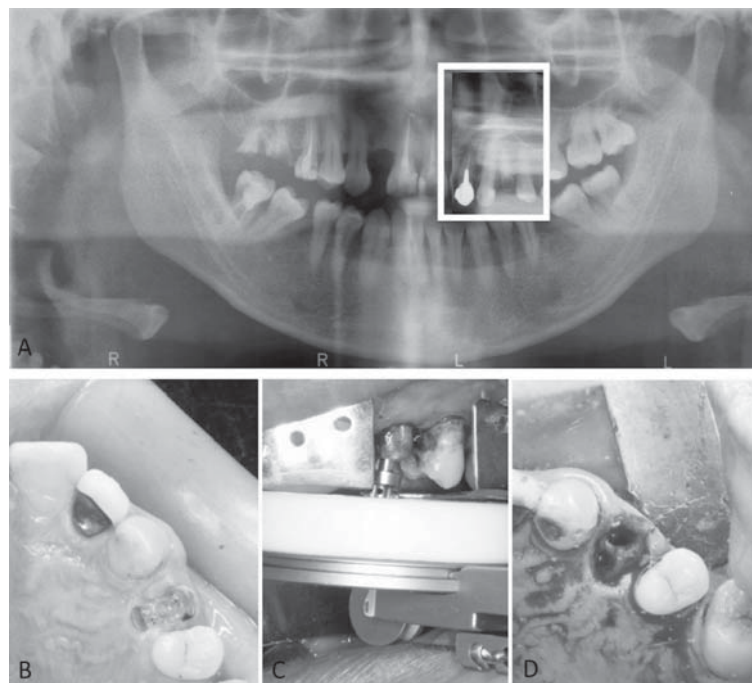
A. Panoramic radiograph shows severe decay of the left maxillary first premolar. B. The clinical picture of the severely decayed left maxillary first premolar. C. Support tray and assembled vertical tooth extraction system to achieve axial alignment. D. Extracted dental socket.
